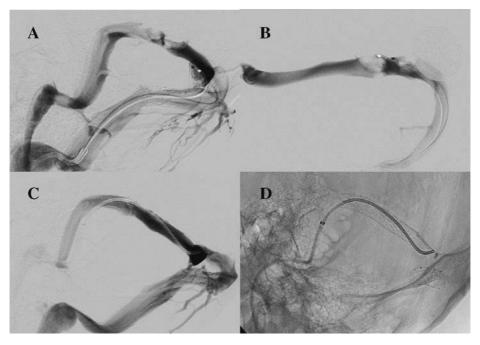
A case of bilateral transverse sinus stenting. (A) Lateral DRCV demonstrating stented right transverse sinus with normal calibre and an obstruction of the left transverse sinus. (B) AP view of left transverse sinus with filling defect. (C) Lateral DRCV demonstrating that the left transverse sinus has also now been stented. (D) Plain film showing the bilateral transverse sinus stents in situ
